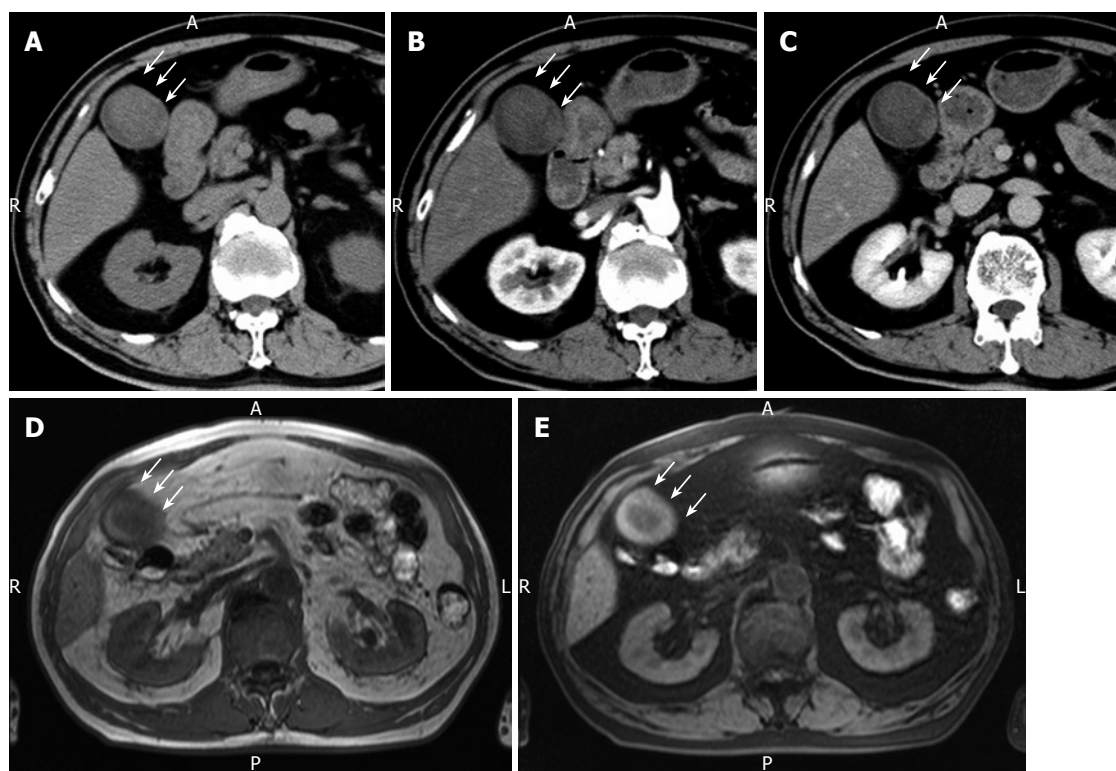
Plain CT. (A) showing a relatively low-density mass of the fundus measuring 5 cm x 4 cm in diameter, contrast-enhanced CT revealing no positive enhancement of this mass-like lesion in its early (B) and late (C) phases, MRI showing a mass in the fundus with a slightly low intensity on T1-weighted images (D) and a slightly high intensity on T2-weighted images (E). White arrow represents the mass-like lesion of the fundus.
